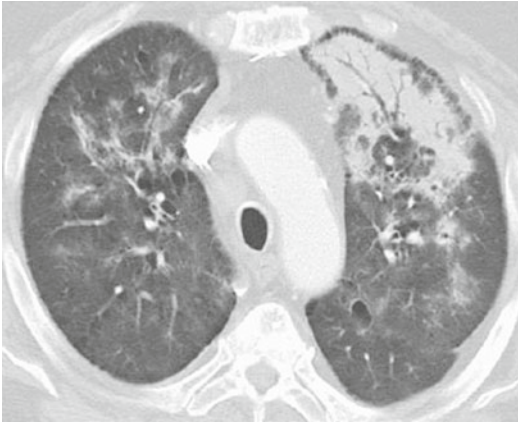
Organizing pneumonia after mitomycin-C. A 70-year-old man who developed mild shortness of breath after mitomycin-C therapy. CT shows a more characteristic appearance of organizing pneumonia with peripheral, upper lobe consolidation. Paraseptal emphysema was also present which prevented the consolidation from completely abutting the pleura
